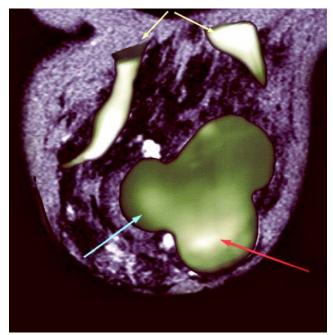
Fusion of the MRI and CTLM images shows that the CTLM and MRI demonstrate the same angiogenesis. The red arrow points to a malignant phylloides tumor, while the blue arrow indicates a fibroadenoma.
